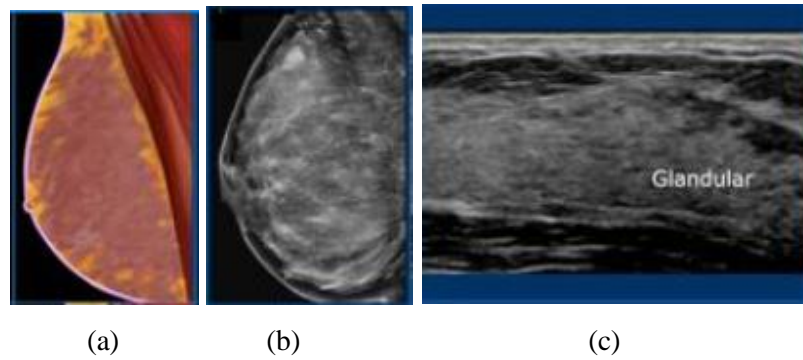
Example of a (a) Breast Anatomy, (b) Mammography, and (c) breast ultrasound imaging [45].
